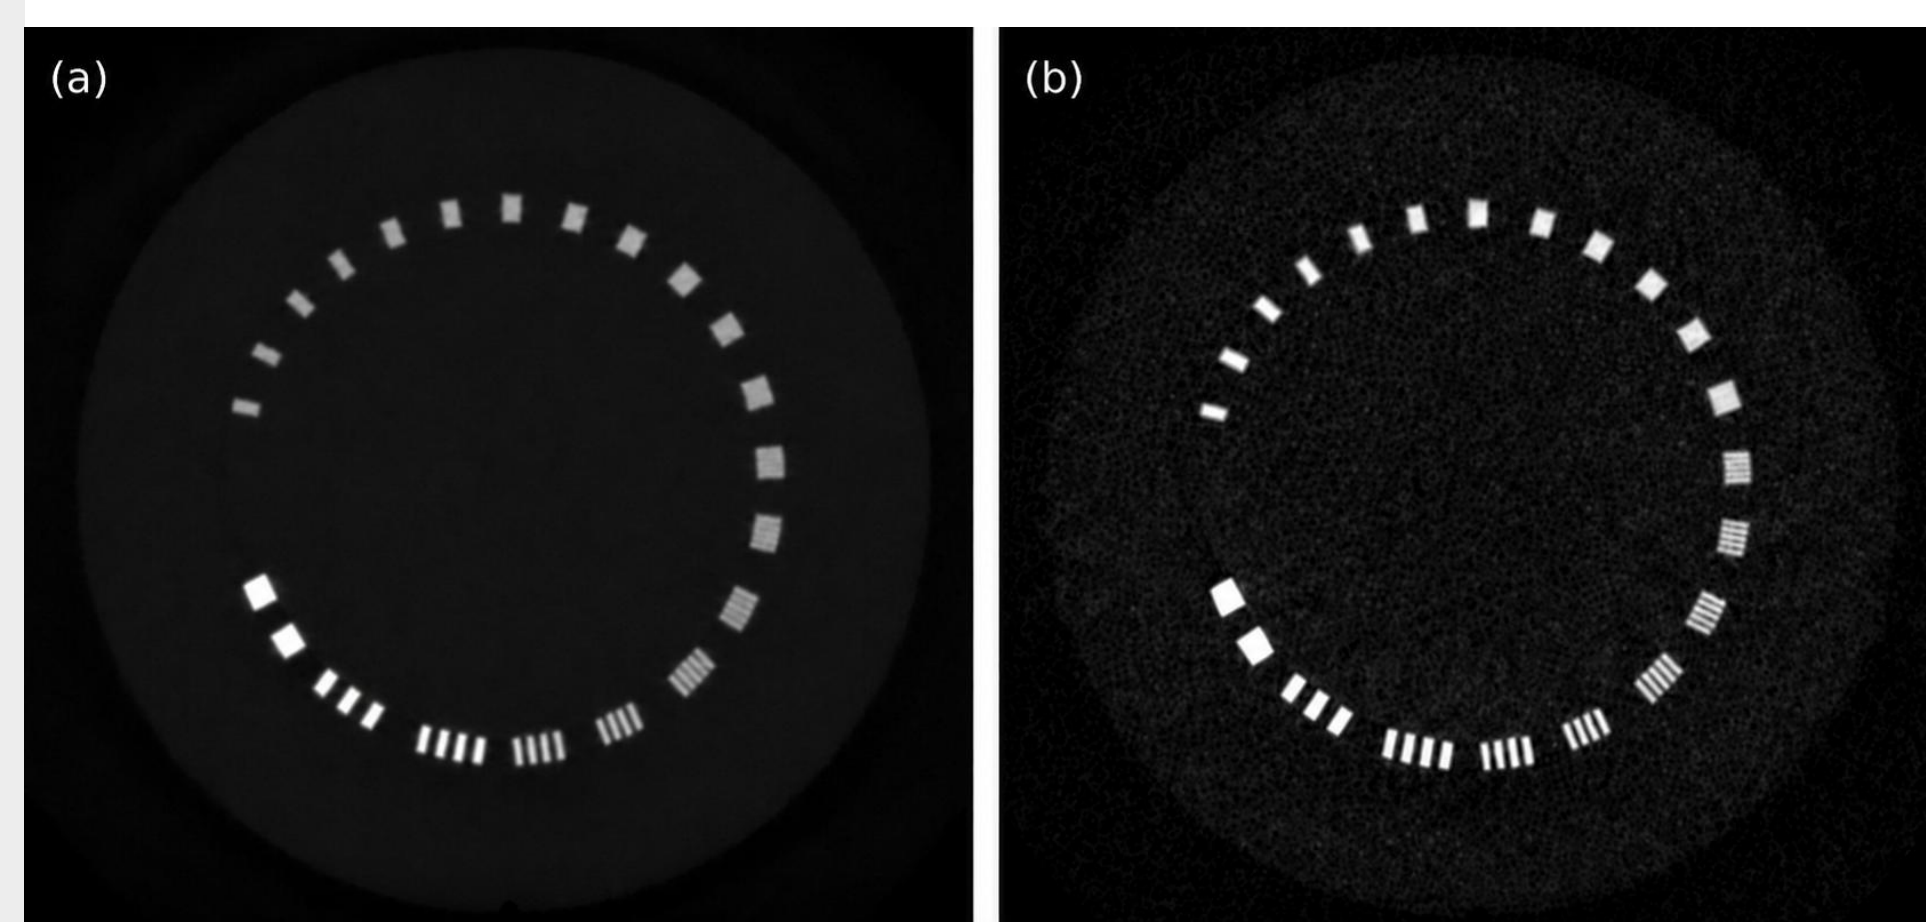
Spatial resolution analysis from a CatPhan scanned with our new C-arm linac imaging panel using iCBCT reconstruction and (a) smooth filter with high noise suppression, (b) sharp filter with low noise suppression.
